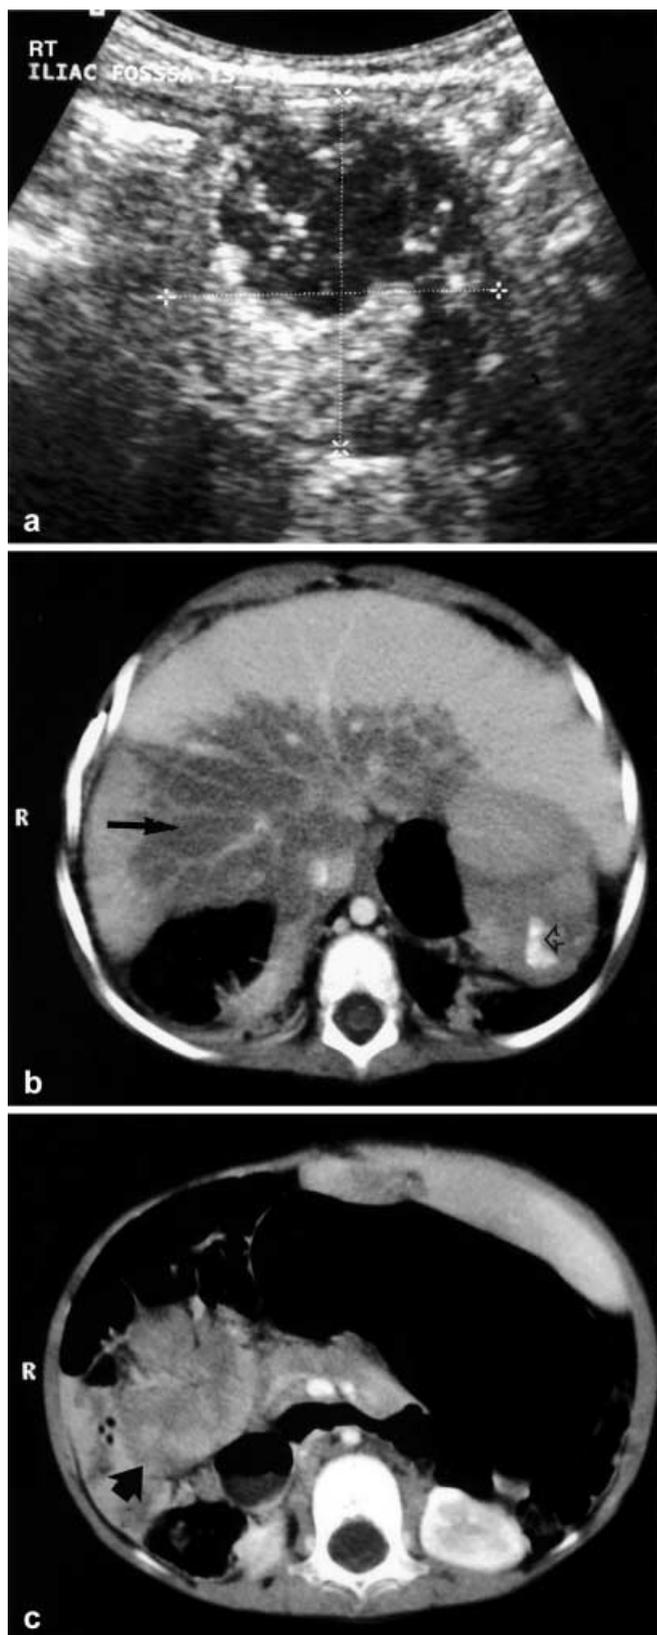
a Transverse US reveals a solid, heterogeneous 5-cm mass, which was separate from bowel and contained cystic locules inferiorly. b Contrast-enhanced CT demonstrates infiltration of the liver (*arrow*) and incidental splenic calcification (*arrowhead*). c CT also shows that the right abdominal soft-tissue density mass is of soft-tissue density (*arrow*) and is surrounded by mesenteric vessels with matted loops of bowel inferiorly. No significant enhancement was seen
